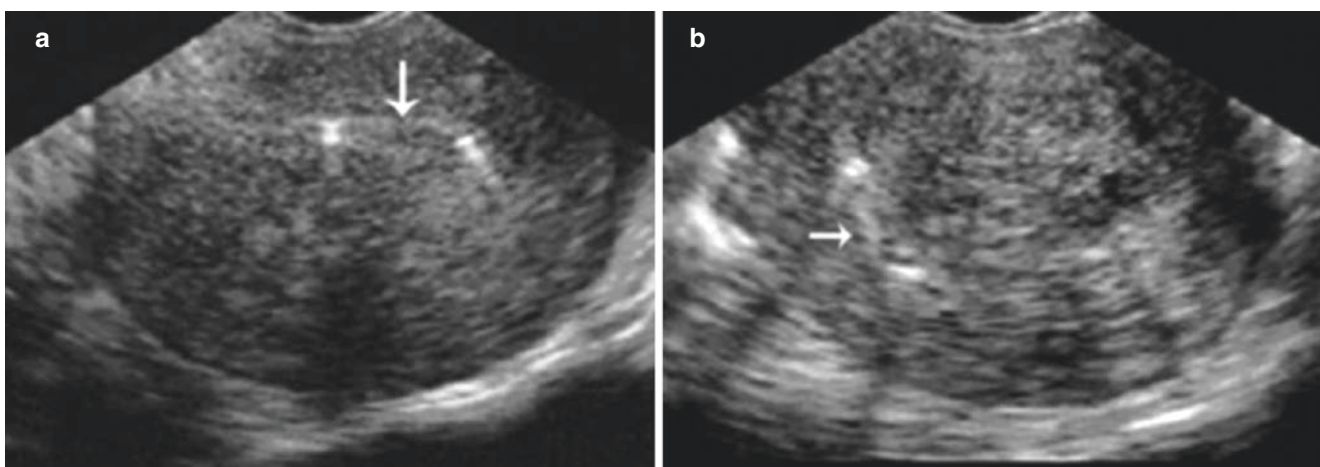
Adenomyosis (II). (a) Sonogram shows the thickened anterior myometrium and backward distorted endometrium (arrow). (b) Sonogram shows the thickened posterior myometrium and distorted endometrium (arrow)
